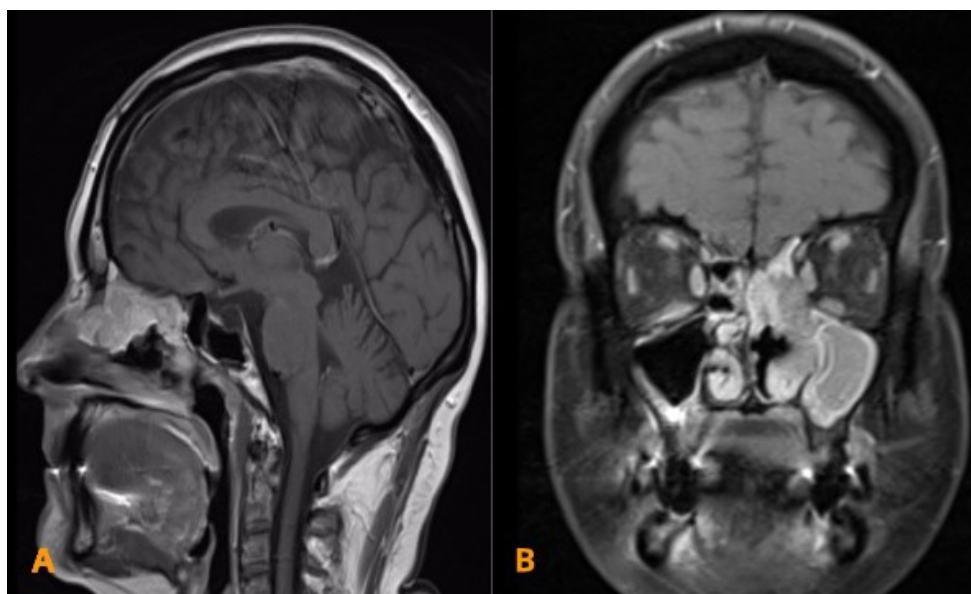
Contrast enhanced brain MRI, T1 weighted scans sagittal (A) and coronal (B) showing an anterior skull base tumor growing into the sinonasal cavity.
